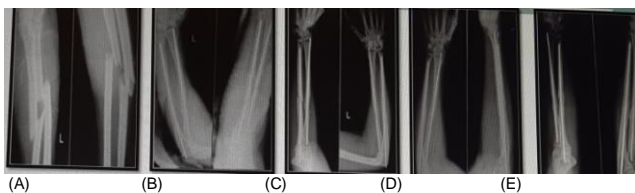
A Preoperative radiographic image. B, C, D and E, Postoperative radiographic images after using intramedullary nail
